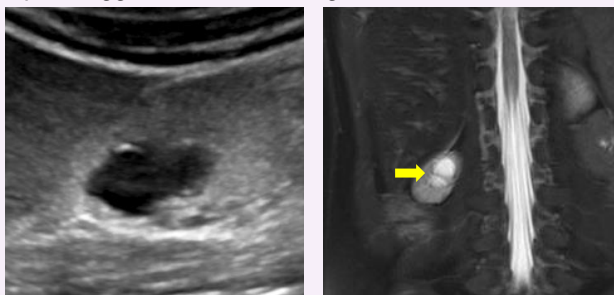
6-year-old girl with ESRF on haemodialysis. Only one renal cyst with thin septa was detected at right upper pole on US (Bosniak grade II). MRI on the same day showed multiple bilateral renal cysts, diagnostic of ACKD. T2W HASTE FS coronal MRI clearly depicting the right upper pole renal cyst in fact contained thickened septa, suggestive of Bosniak grade IIF instead.
